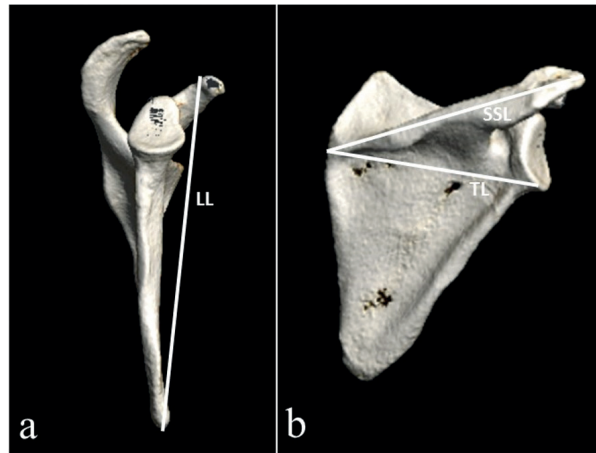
CT scan with volume rendering reconstruction: (a) right scapula, lateral view. LL: Longitudinal length of the scapula (b) right scapula, posterior view. TL: transverse length of the scapula. SSL: length of the scapular spine.
